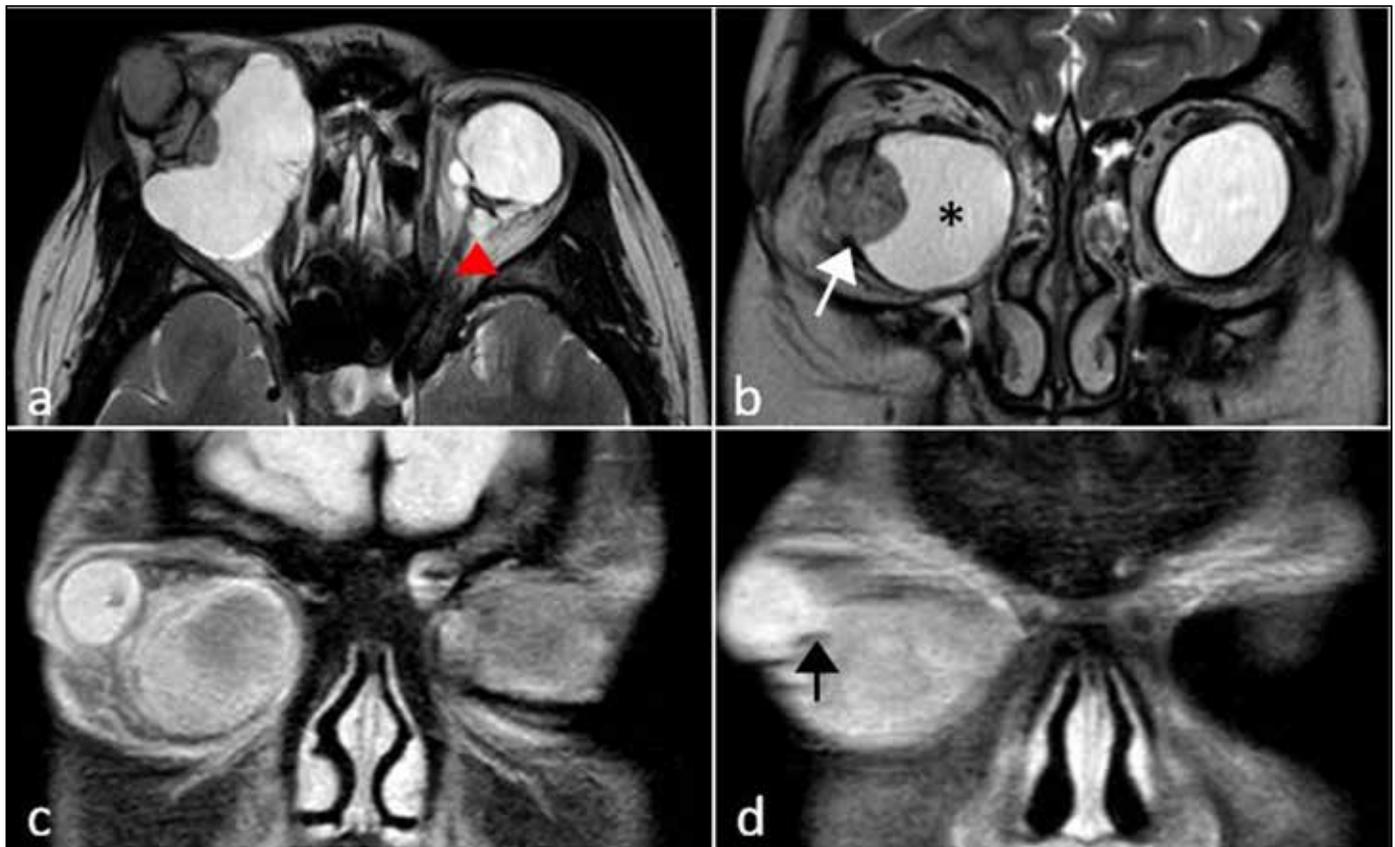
Magnetic Resonance Imaging (MRI) scan of the orbit (a) Left eye, T2 weighted image (axial view) showing small multiple hyper-intense cystic lesions behind the posterior sclera (red arrow head). (b) Right eye, T2 weighted image (coronal view) showing a hyper-intense cystic lesion (asterisk) with a hypo-intense solid component (white arrow). (c) Right eye, post contrast scan showing enhancement of the lesion as well as the eyeball. (d) Right eye (coronal view) showing anterior attachment of the cystic lesion to the globe (black arrow).
